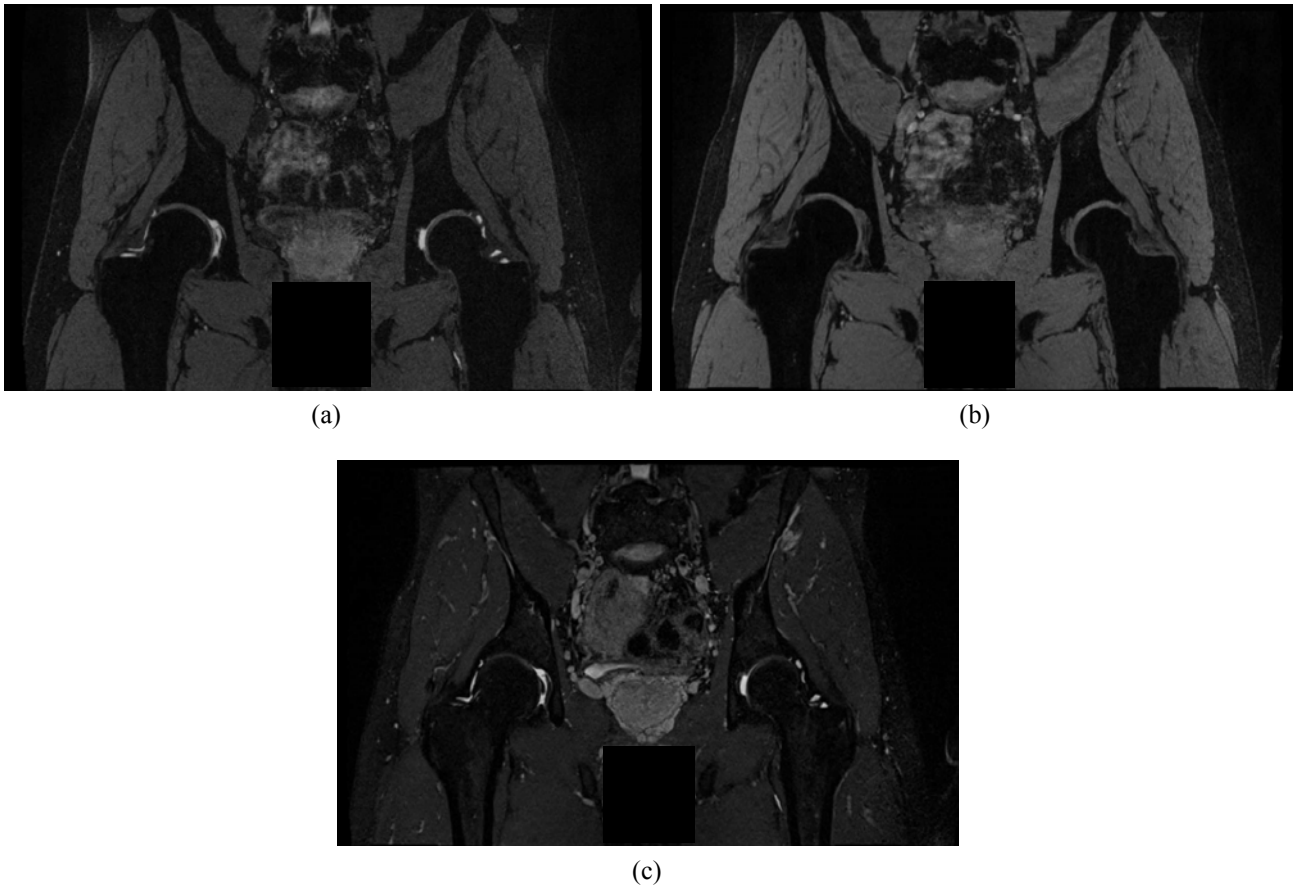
High-resolution large field-of-view MR images within the hip region acquired at 3.0 T from the same subject: (a) water-excitation DESS ( $0.67 \times 0.67 \times 0.61 \text{ mm}^3$ ), (b) MEDIC ( $0.65 \times 0.65 \times 0.70 \text{ mm}^3$ ) and (c) 3D proton density-weighted fat suppression SPACE ( $0.77 \times 0.77 \times 0.70 \text{ mm}^3$ ).
